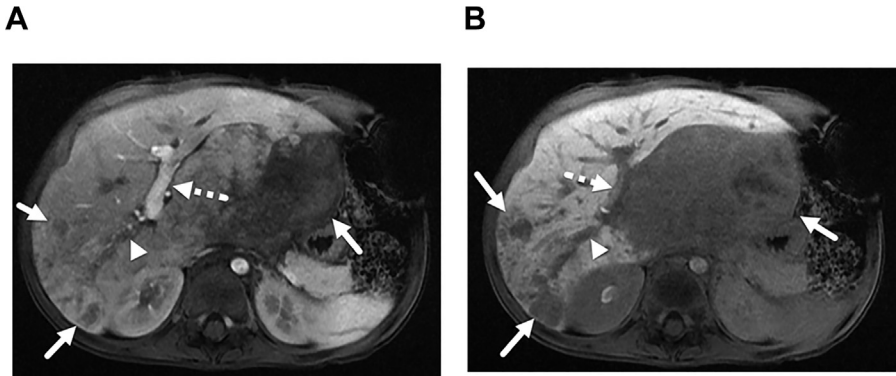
HB, PRETEXT II, positive P and F. (A) Hepatocyte specific contrast enhanced MRI, axial T1-weighted image obtained in the portal venous phase of enhancement after administration of a hepatocyte specific contrast agent shows enhancement of the left portal vein (*dashed arrow*), thrombosis of the right portal vein (*arrowhead*), and multifocal tumor (*arrows*). (B) The multifocal tumor is seen better on the hepatocyte phase of imaging (annotations point to the same landmarks).
